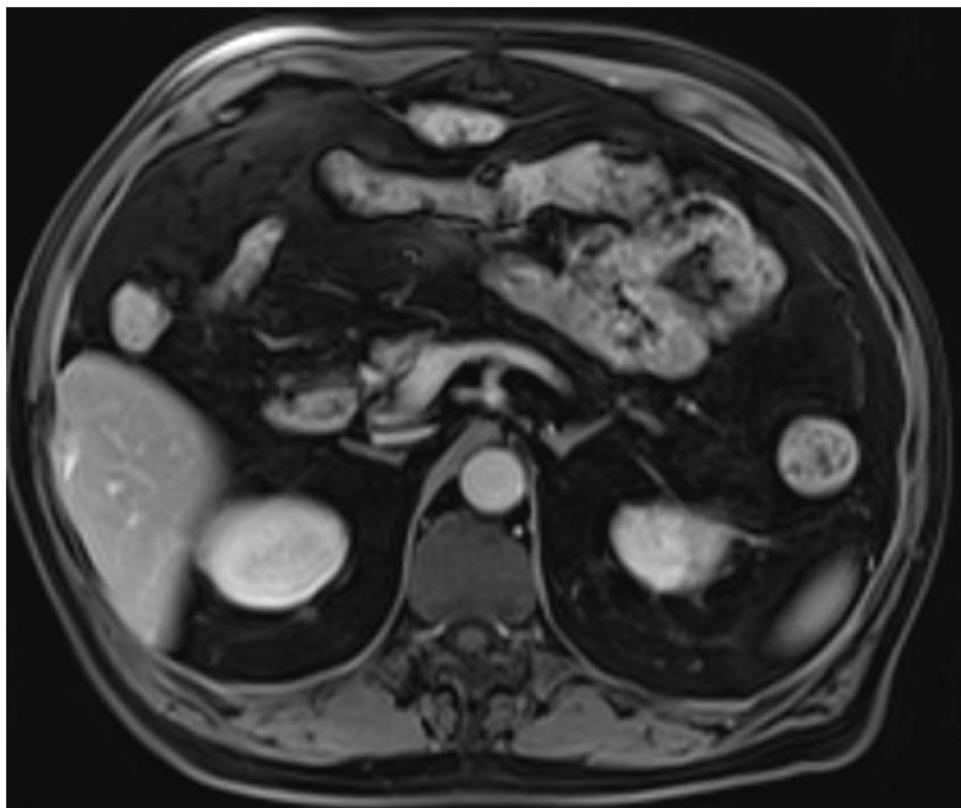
T1-weighted images shows the mass as an isointense area, compared with the kidneys.
